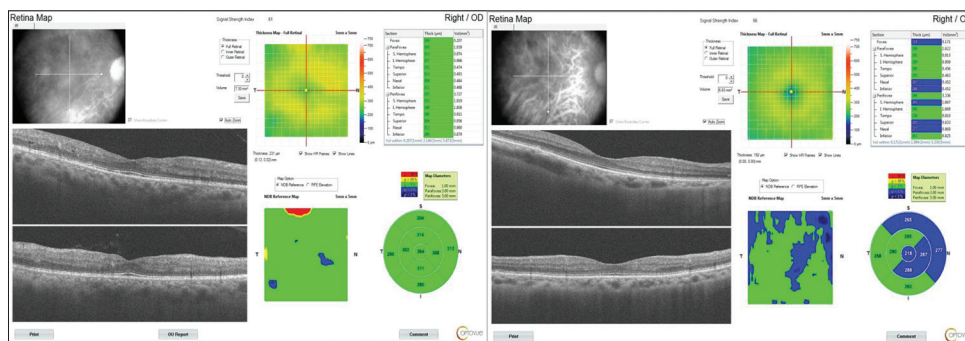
CT of preinjection and postinjection case no. 5. OCT, optical coherence tomography.
